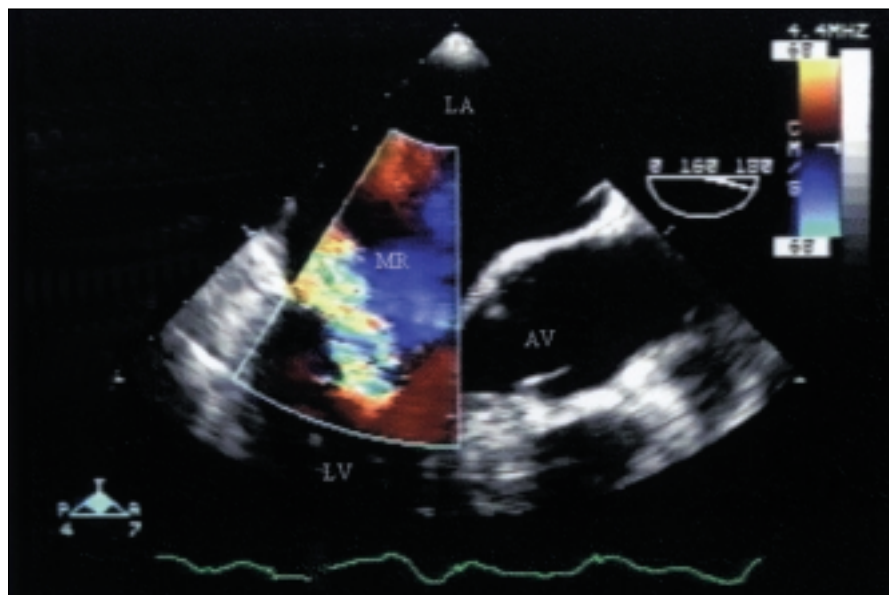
Transesophageal echocardiogram (color Doppler) demonstration of severe mitral regurgitation (MR) associated with the flail anterior mitral leaflet seen in Figure 1. (LV, left ventricle; LA, left atrium; AV, aortic valve.)
